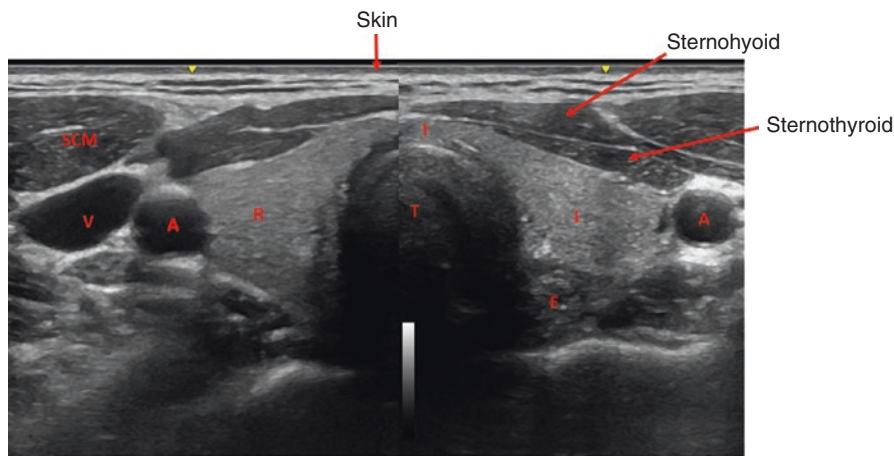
Ultrasound image of the thyroid gland. *T* trachea, *R* right thyroid lobe, *L* left thyroid lobe, *I* thyroid isthmus, *A* carotid artery, *SCM* sternocleidomastoid muscle, *E* esophagus, *V* jugular vein
